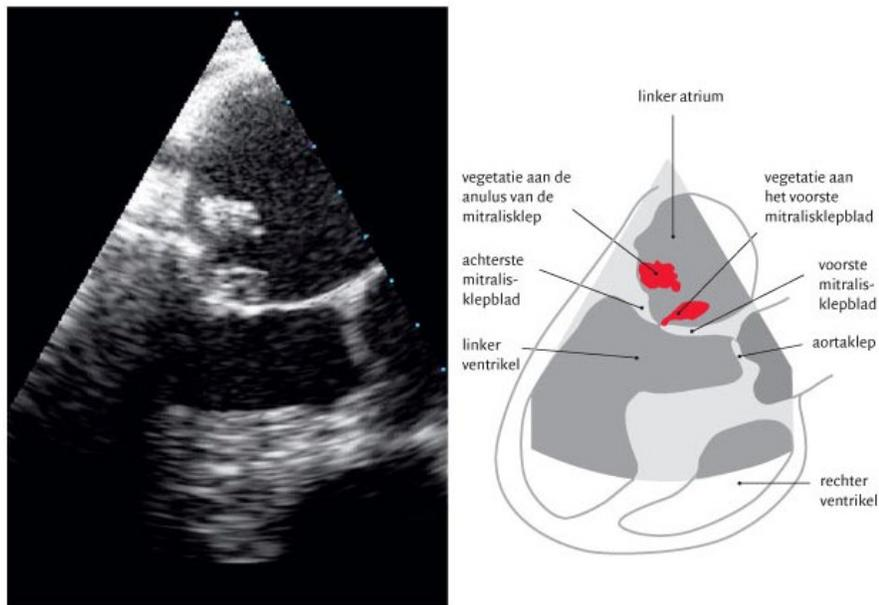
Transesophageal echocardiography of patient A on day 7 of hospitalization
